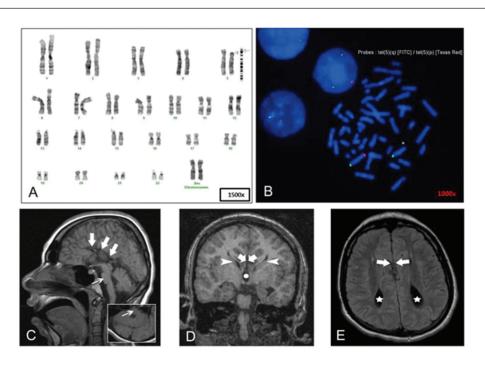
(A). G-banded karyotype (x 1500 magnification) showing 46,XX,del(5)(p15). Arrow indicates the breakpoint on p-arm of chromosome 5. (B). FISH (x 1000 magnification) using telomeric probes (Aquarius) for chromosome 5p (red) and 5q(green). Arrow indicates the absence of FISH signal on 5p confirming the deletion. (C-E). Brain MRI demonstrating complete corpus agenesis of corpus callosum (thick straight arrows in C, D and E), radial arrangement of medial hemispheric sulci, absence of cingulate sulcus, splaying of anterior part of the lateral ventricles (arrowheads in D), colpocephaly (stars pointing to the enlarged occipital horns of the lateral ventricle in E) and high riding third ventricle (a single circle in D) and pontine hypoplasia (a single thin straight arrow in C and inset).
